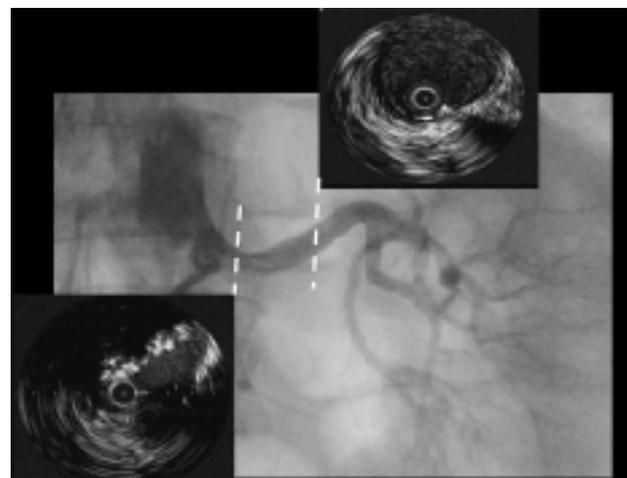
Angiogram and corresponding intravascular ultrasound cross-sections obtained before stent placement. The lower intravascular ultrasound image shows the extent of renal artery narrowing.
